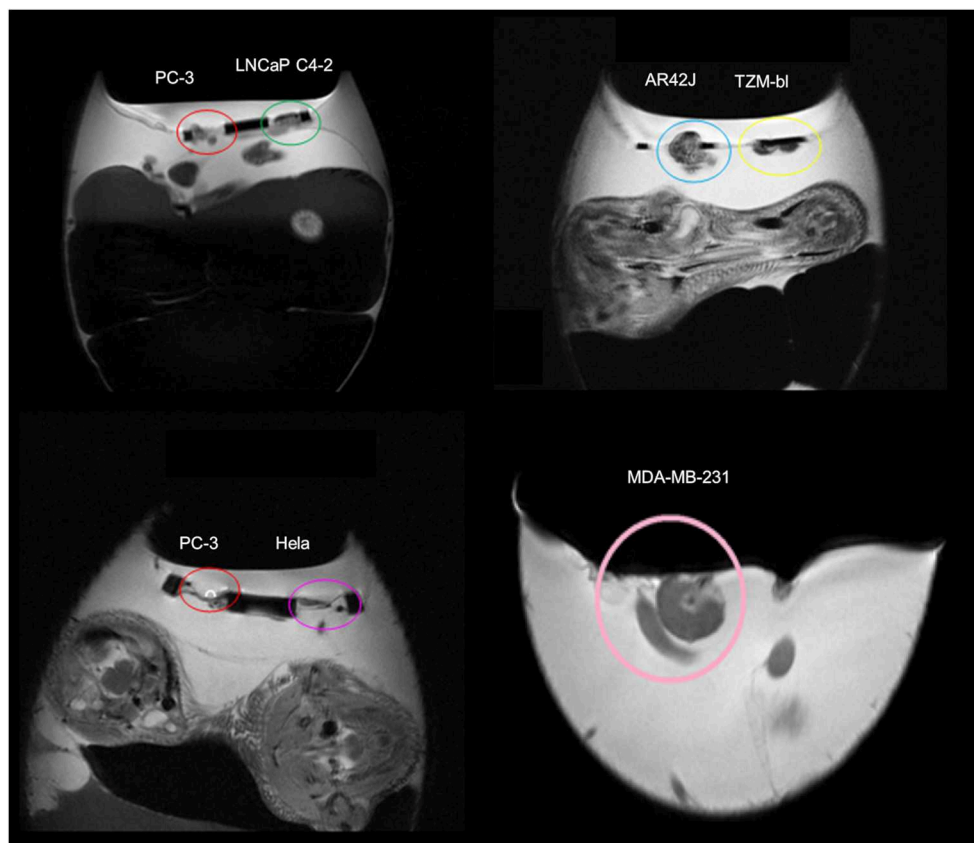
Magnetic resonance images (MRI) of xenotransplanted tumors grown on the chorioallantoic membrane (CAM) from different cell lines (prostate cancer: PC-3, LNCaP C4-2; pancreas cancer: AR42J; adenocarcinoma: T2M-bl; cervical cancer: HELA; breast cancer: MDA-MB-231). Unpublished imaging material provided by Winter and Li.
